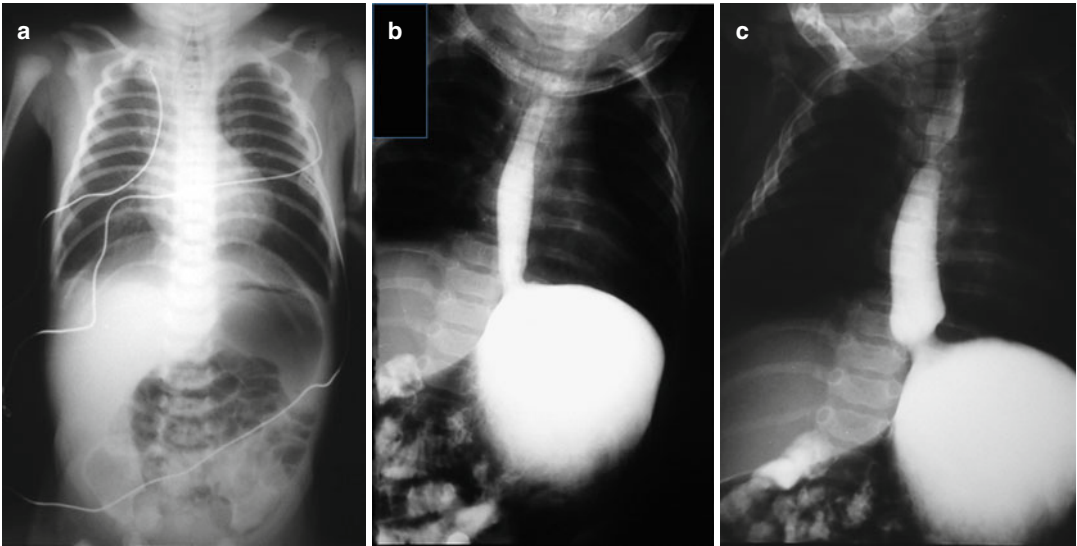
Infant with spasm of the pyloric muscle and gastroesophageal reflux. (a) Plain film shows air gastric distention and the air passage in the bowel loops. (b, c)
